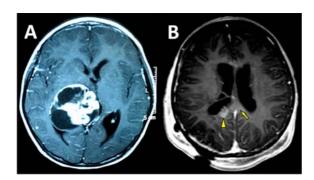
(A) Contrast-enhanced cranial MRI showing (A) a solid cystic tumor at the right thalamus; (B) Postoperative MRI showing lesions suspicious of residual tumors at the medial aspect of posterior horn of the right lateral ventricle (arrowhead) and the splenium of corpus collosum (arrow).
